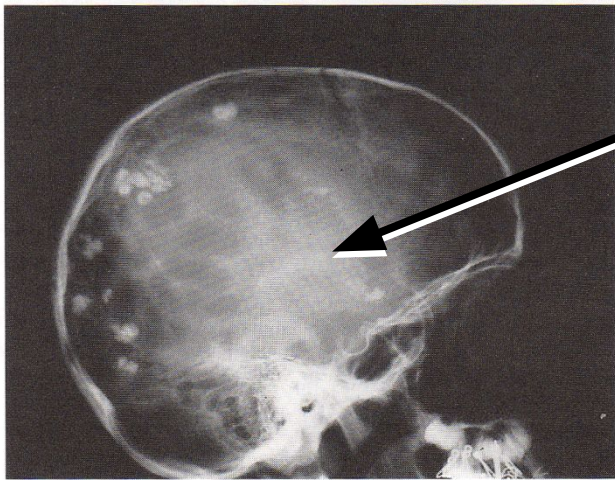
Intracerebral calcification discovered fortuitously in a 10 year old girl, on a dental panoramic radiograph asked for by a dentist. The girl had unilateral retinochoroiditis and an IQ of 80. (Courtesy of Dr J. Couvreur).
